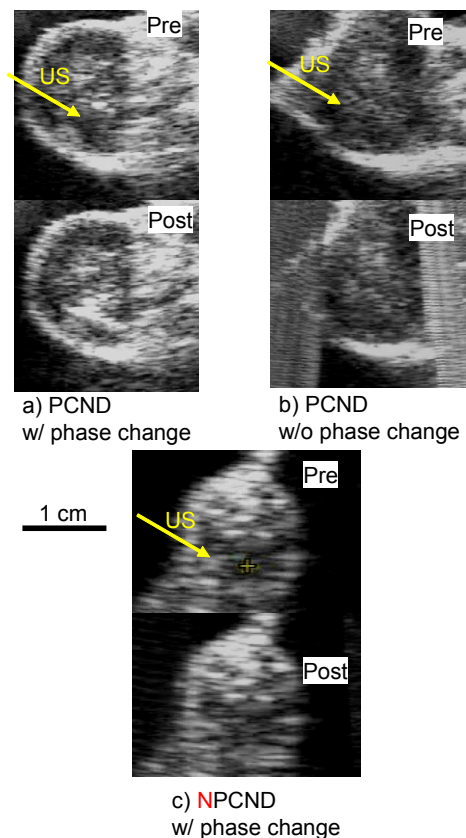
Change of tumor tissue in B-mode image on 1-MHz ultrasound exposure
